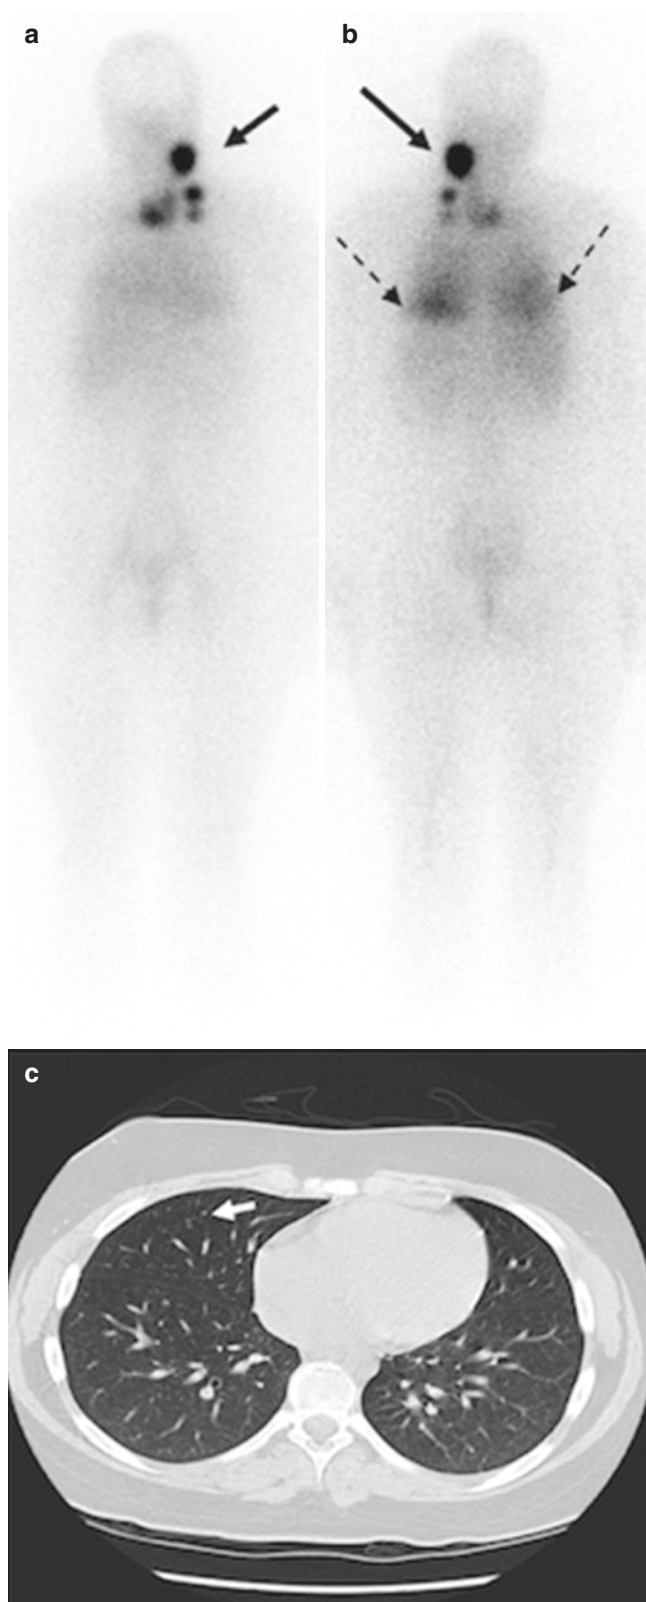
Imaging with $^{123}\text{I}]\text{NaI}$ or low-dose $^{131}\text{I}]\text{NaI}$ provides a highly sensitive and specific way to detect the metastatic spread of thyroid cancer to sites of disease outside of the neck. In this case, anterior (a) and posterior (b) planar whole-body images taken 7 days after a therapeutic dose of $^{131}\text{I}]\text{NaI}$ demonstrate regional lymph node metastases in the neck (solid arrow) and distant metastatic spread to the small nodules in the lung bases (dashed arrows). Lung metastases were not as easily seen by CT (c, arrow indicates a single small nodule) but were readily apparent in the radioiodine images
